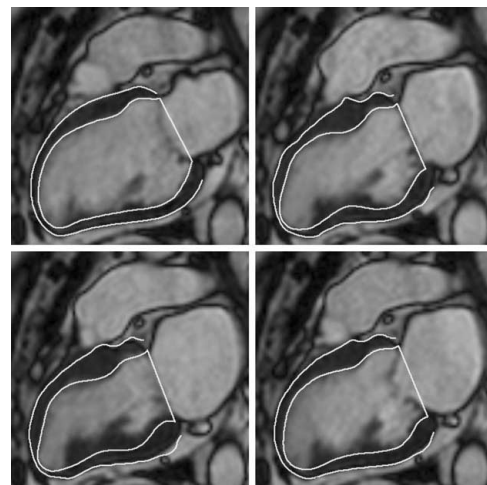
Initialization (upper left) and propagated segmentations of long axis cardiac MR images.
